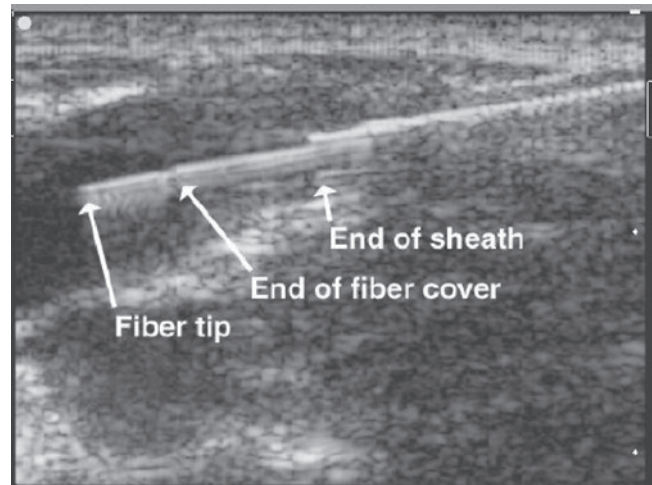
The tip of the fiber is visible using ultrasound.
